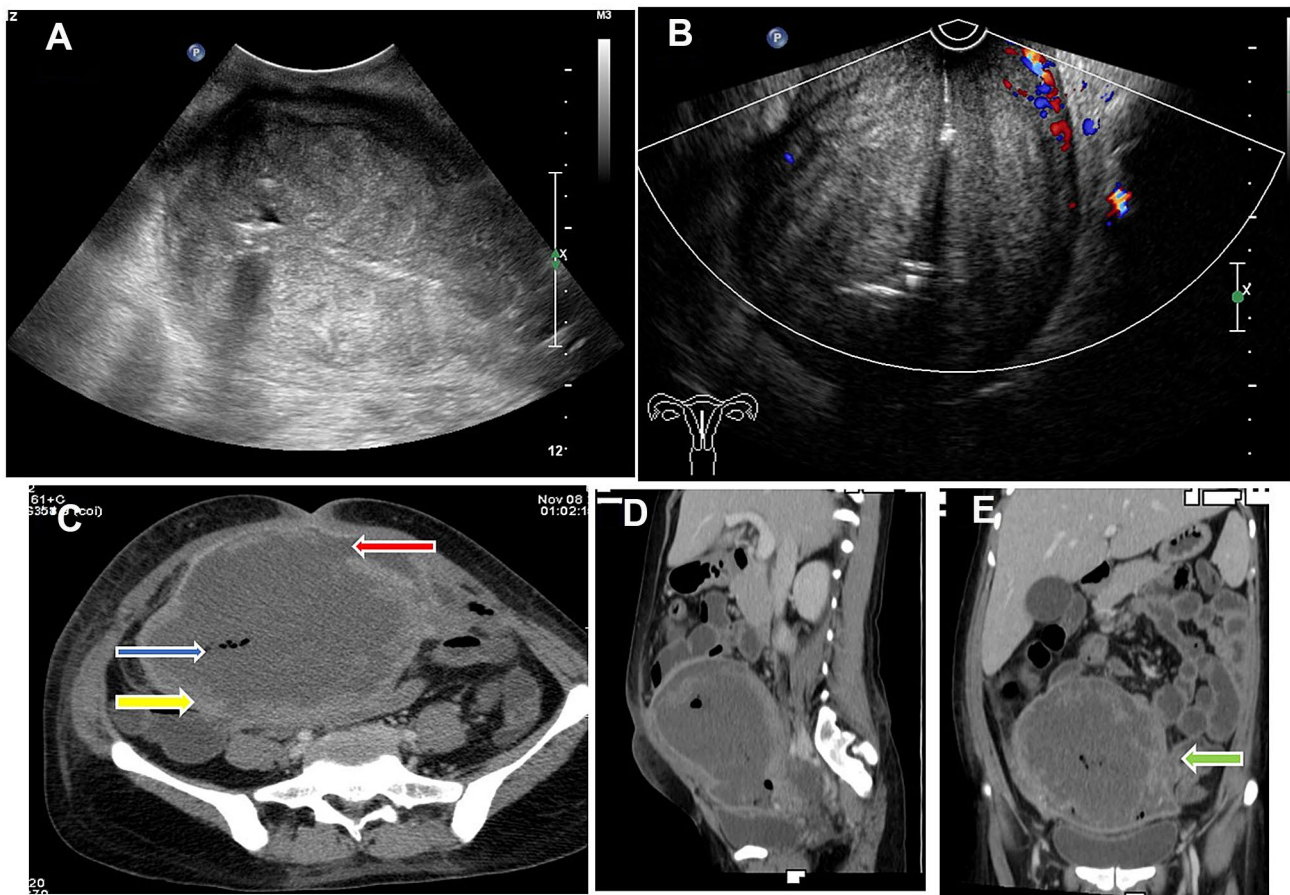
a Transvaginal sonography shows uterus is bulky with heterogeneous myometrium and indistinct endo-myometrial interface, b color Doppler imaging demonstrates vascularity only in peripheral myometrium with multiple air foci (yellow arrow), c CECT abdomen axial image shows bulky uterus with central non-enhancing area with multiple air foci within (blue arrow). Normal myometrium is
